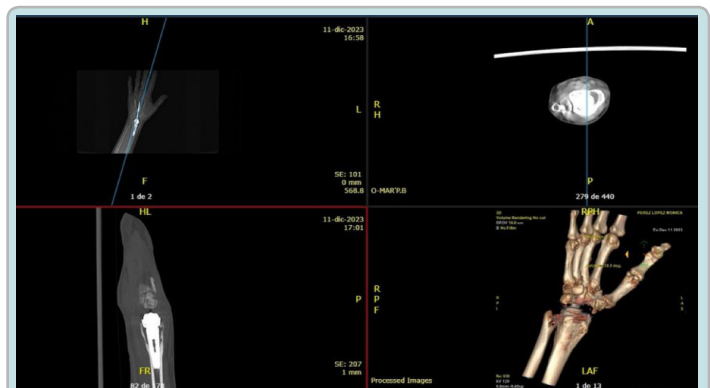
CT scan of the right wrist due to suspected prosthetic infection.
